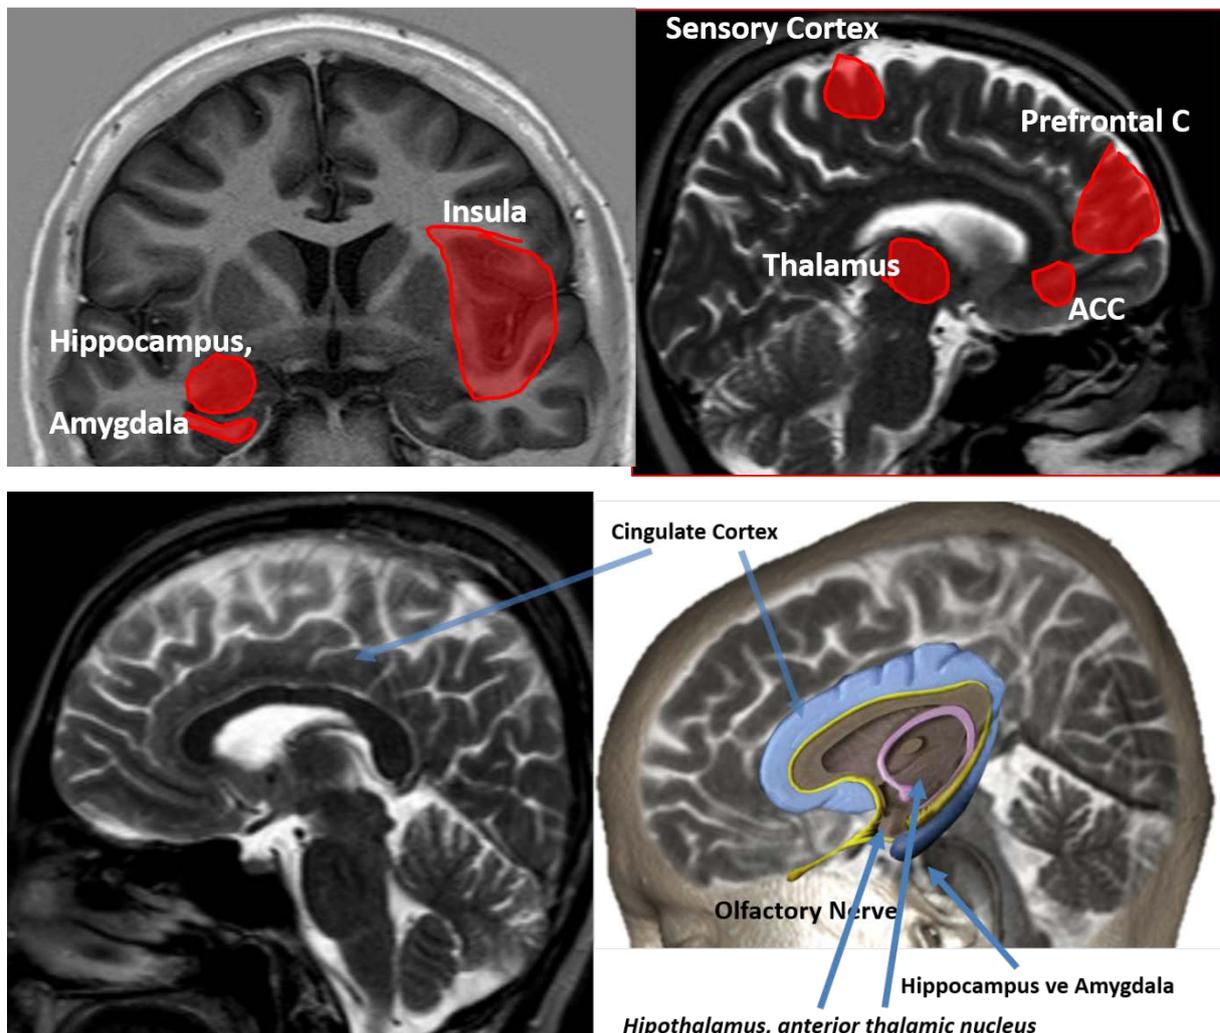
Main anatomical regions of limbic system shown on Coronal T1(upper right) and sagittal T2 (upper left), Sagittal T2 (lower images) MR images of the brain.
